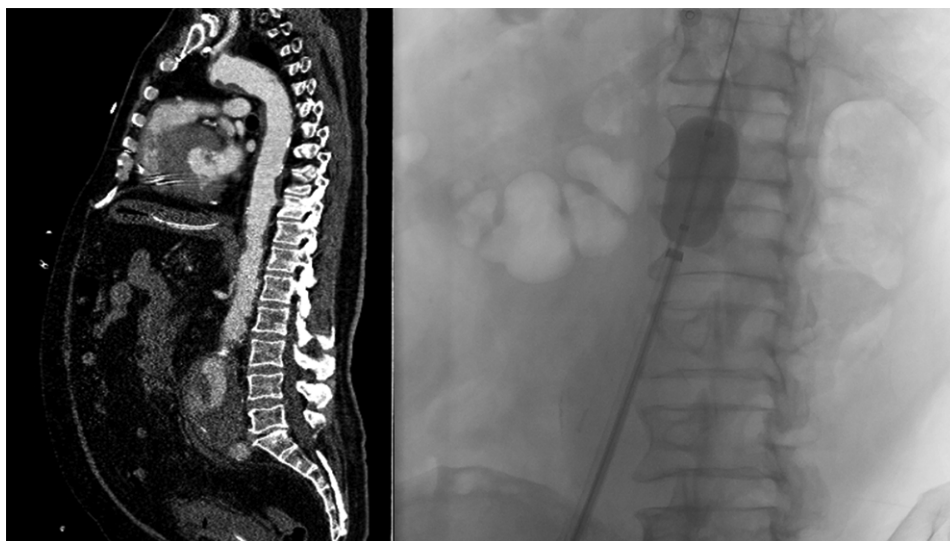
Patient with a ruptured AAA and hypotensive shock. The preoperative sagittal CT view shows that the entire thoracic and upper abdominal aorta is very shaggy. Emergency endovascular procedure was initiated by inflating a balloon to occlude the visceral aorta to achieve temporary blood pressure control. The balloon was placed unplanned in the visceral aortic segment at the level of L1 and L2 vertebrae resulting in embolization into the mesenteric and renal arteries. The patient died after 2 days
